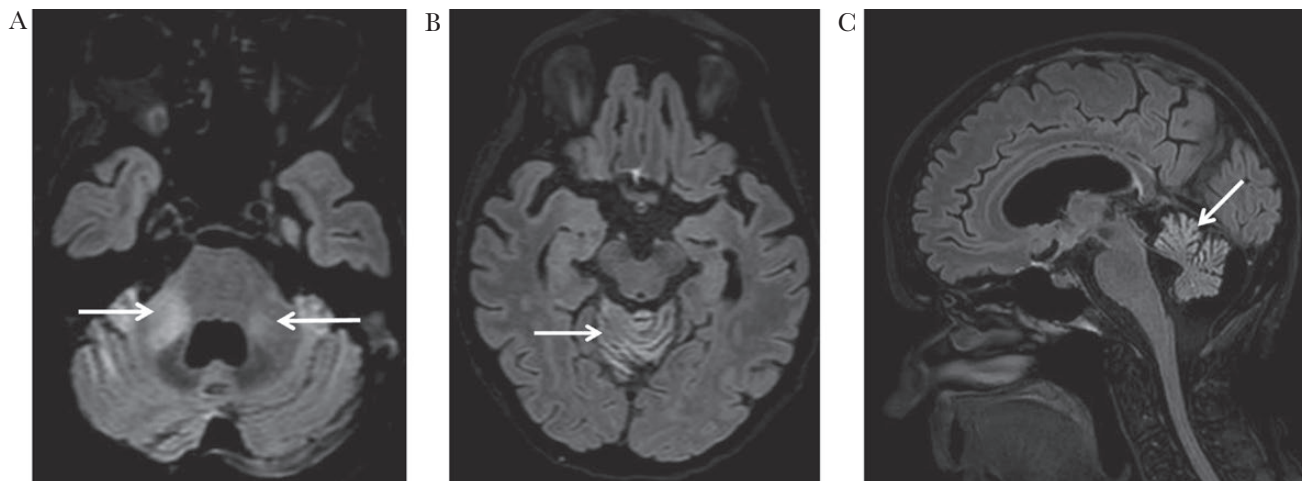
Axial magnetic resonance image (MRI) (A, B) showing, respectively, bilateral hyperintensity in the middle cerebellar peduncle (arrows) and cerebellar vermis cortex hyperintensities (FLAIR-weighted image). Sagittal MRI (C) showing cerebellar cortex hyperintensities (FLAIR-weighted image).
